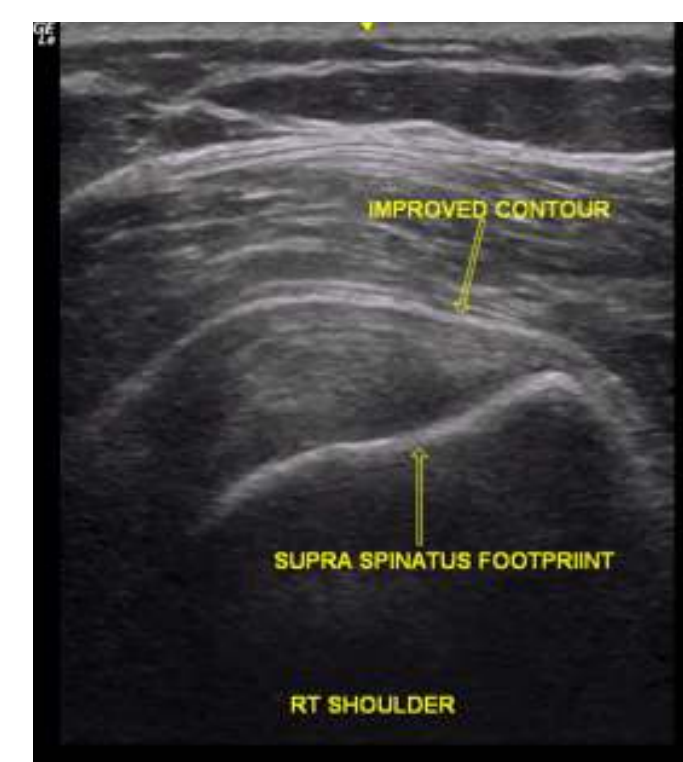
Six month follow up ultrasound image reveals a more robust, hyperechoic, homogeneous supraspinatus tendon echotexture with improvement of the contour defect (arrow)..
